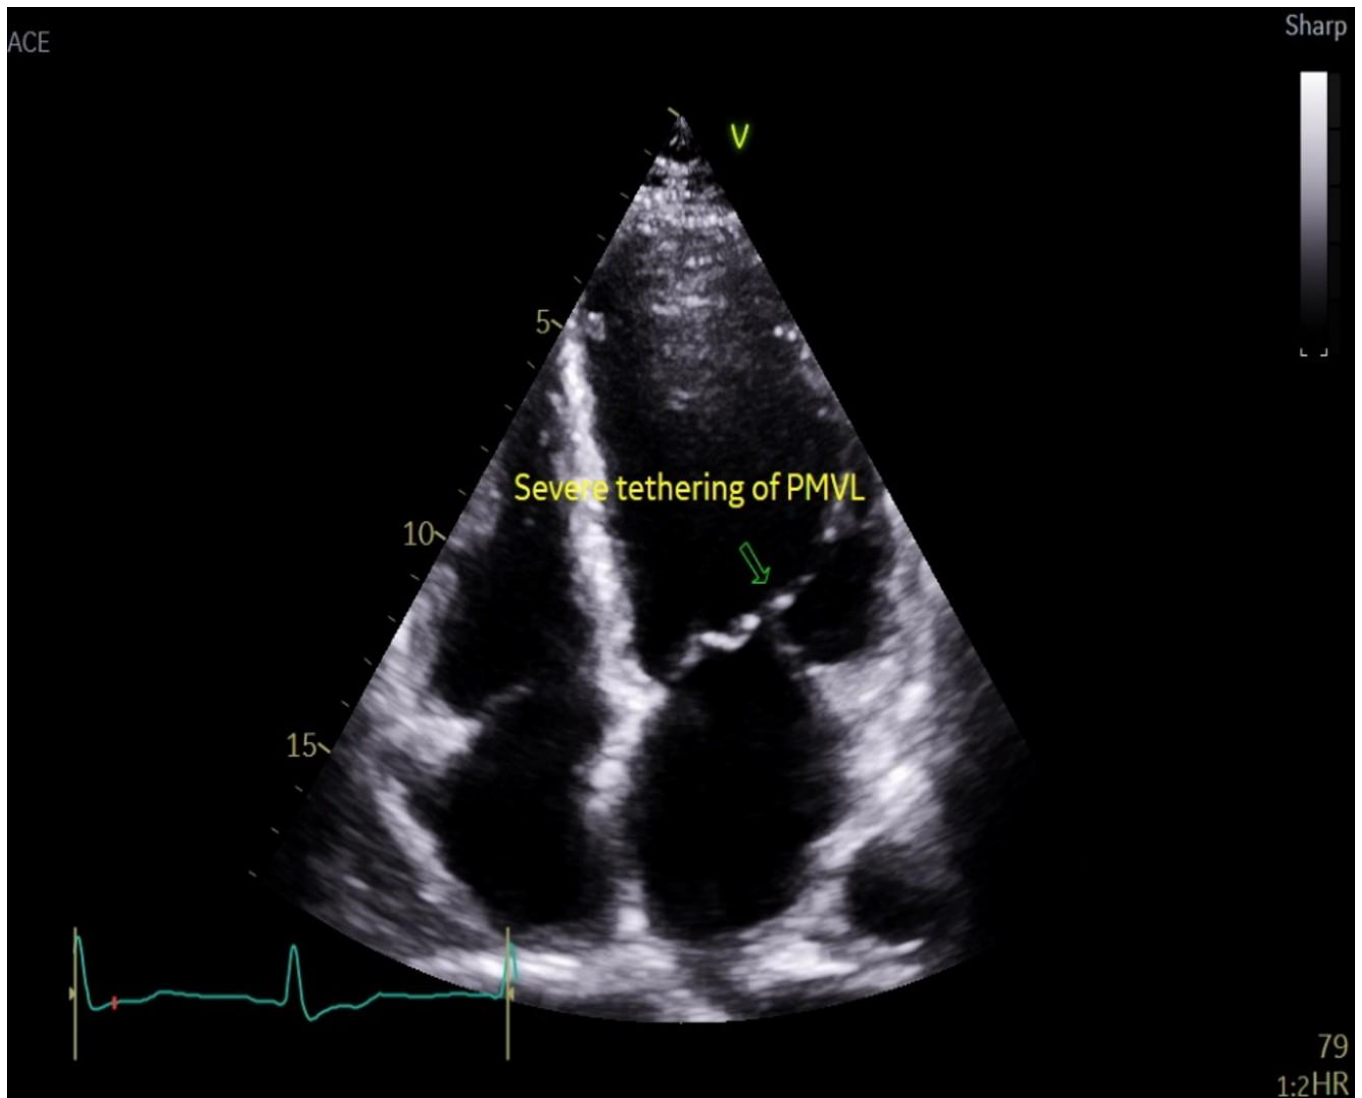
Transthoracic echocardiography apical 4 chamber view showing tethering of posterior leaflet of mitral valve.
